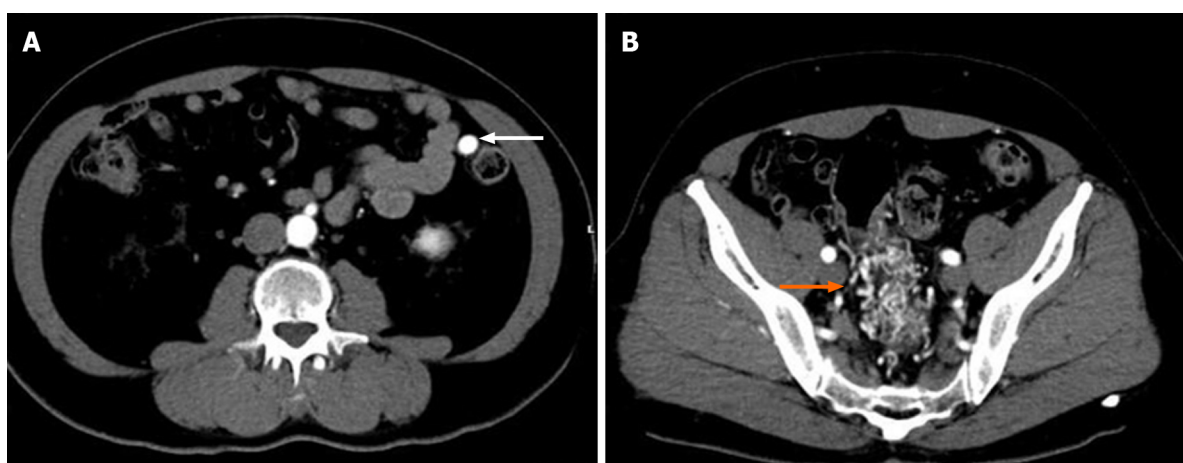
Images from contrast-enhanced abdominal computed tomography. A contrast-enhanced abdominal computed tomography scan showed the nidus of small corkscrew and dilated vessels (orange arrow) and marked early inferior mesenteric vein enhancement (white arrow).
